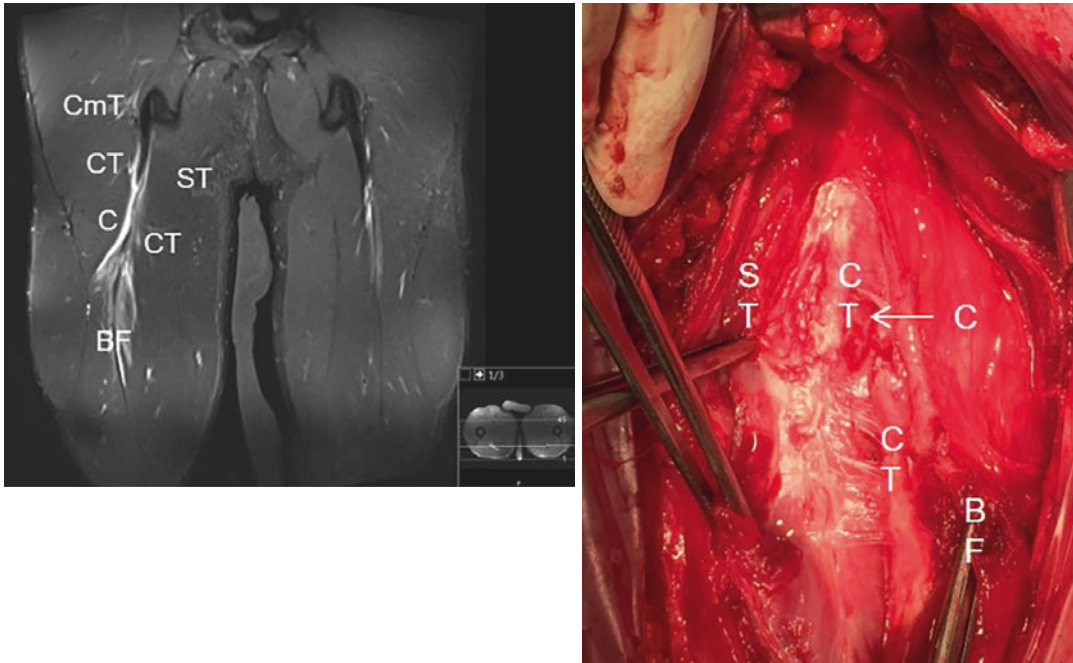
MRI musculotendinous biceps femoris grade 2 injury, showing the disruption and loss of tension in the central tendon. Intraoperative view. *CmT* common
